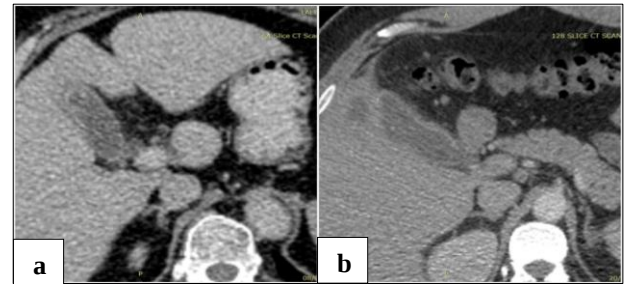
Contrast enhanced CT scan showing type IV enhancement pattern in a thickened gall bladder wall, which is weakly enhancing, thin inner layer with a non-enhancing thin outer layer. The enhancement pattern is shown in (a) and (b).
